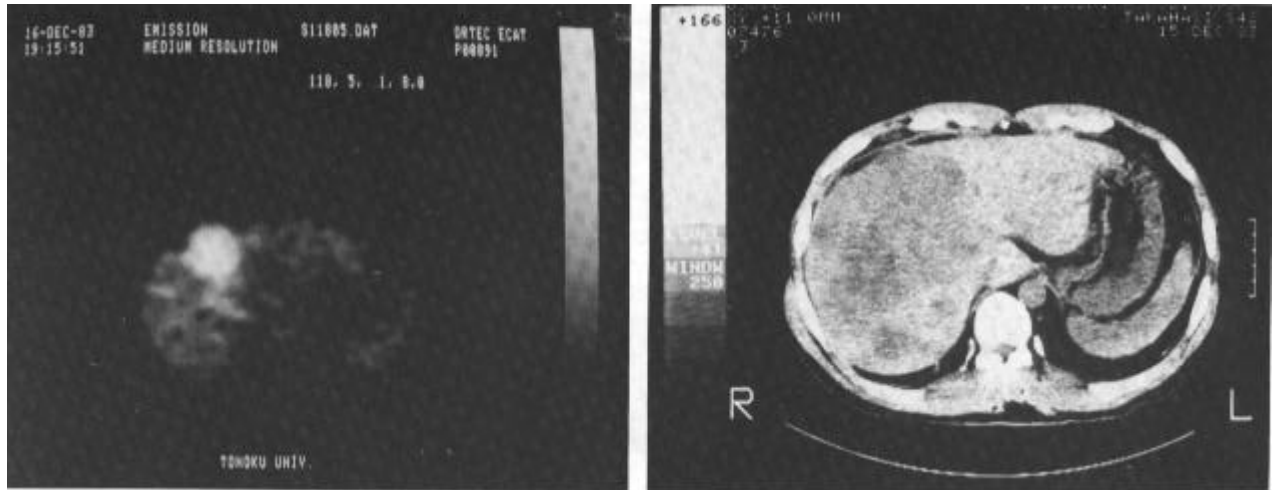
(a): A positron image of hepatoma with ^{18}F FDG (50 min after injection).
